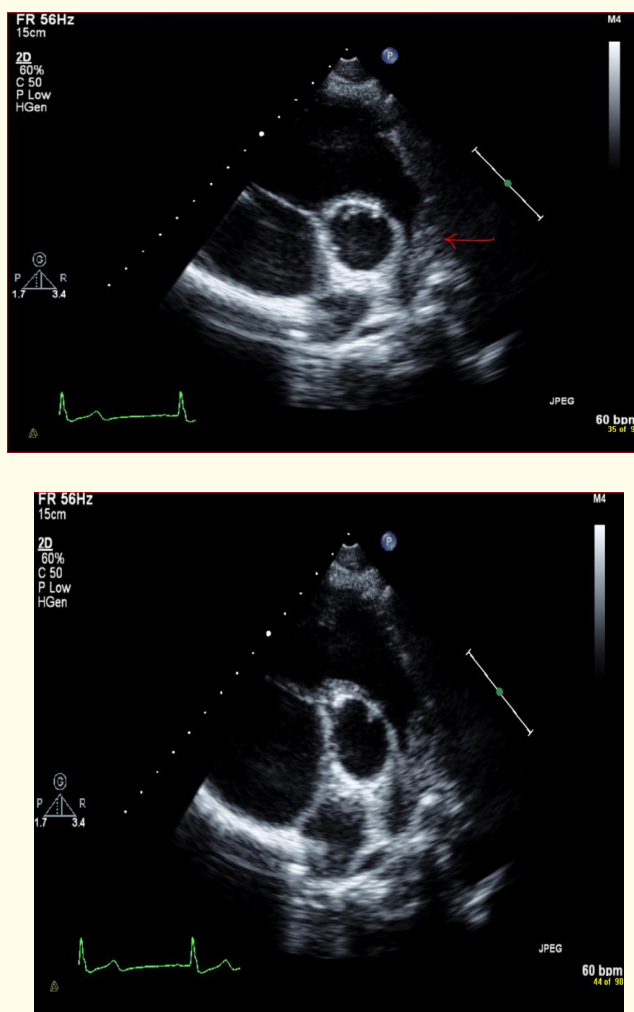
Parasternal short axis view shows: supralvalvular pulmonary stenosis due to mass compressing main pulmonary artery with part of left pulmonary artery (arrow) (figure 1 and 2).
